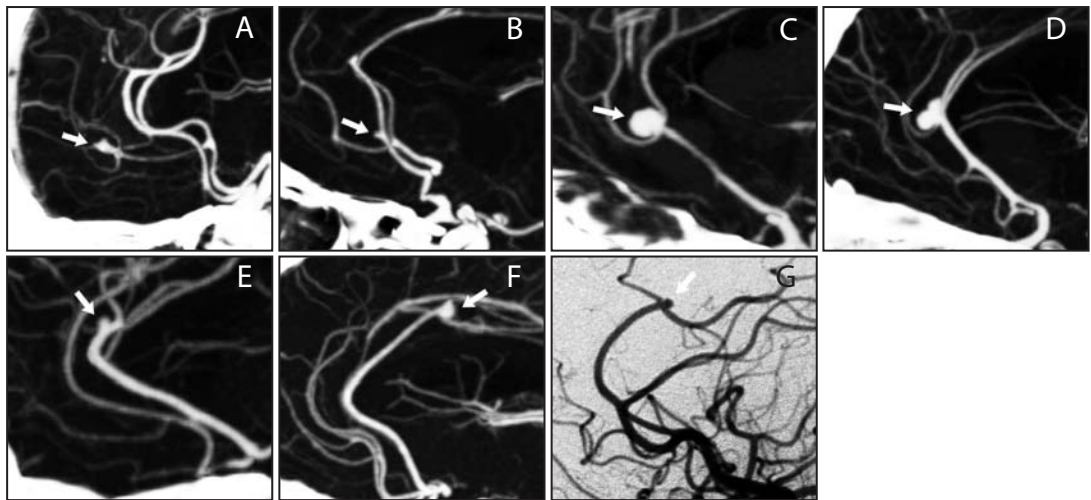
CTA and DSA images of DACA aneurysms at different locations based on microneurosurgical division, arrow marks the aneurysm; (A) Frontobasal, (B) A2 trunk, (C) Inferior A3 segment, (D) Anterior A3 segment, (E) Superior A3 segment, (F) A4 or A5 segments, (G) Distal branches (distal callosomarginal artery).
